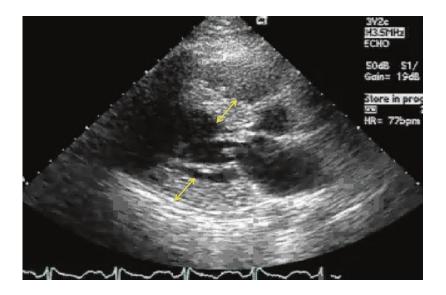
Parasternal long axis: note (yellow arrows) the increased wall thicknesses of anterior-basal septum and the posterior wall
